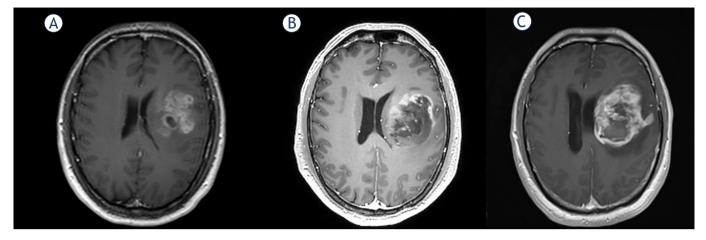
MRI scans in Patient 2 at 0 (A), 18 (B) and 54 (C) days. (T1 with gadolinium sequences).
